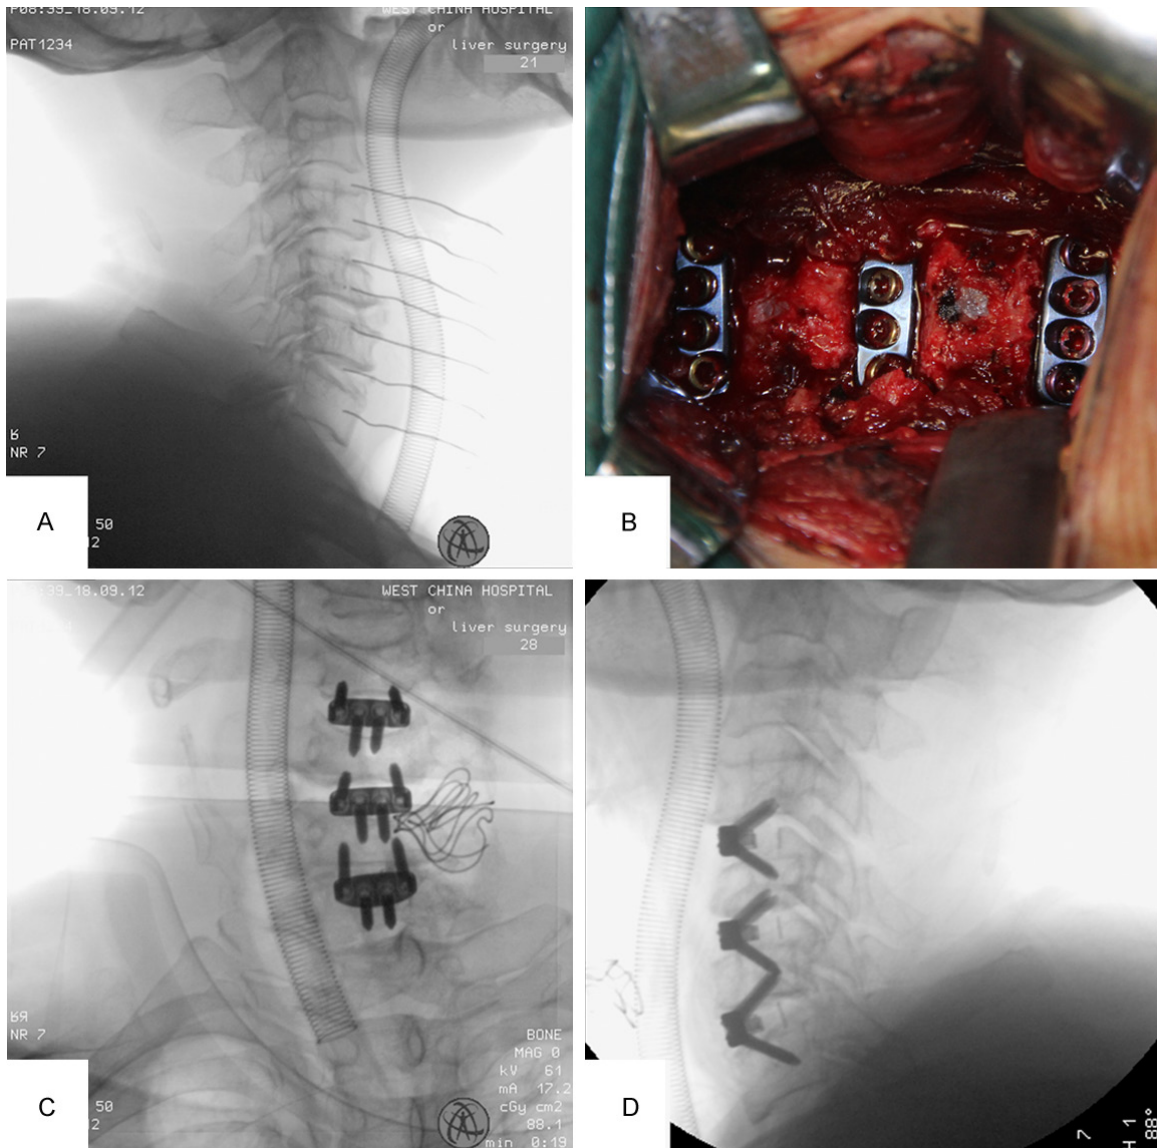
Intra-operative fluoroscopy (A: Determining skin incision with the help of fluoroscopy and metal markers; B: Inserting the three implants and inserting the screws; C and D: Confirming final implant position with the help of fluoroscopic X-rays).
